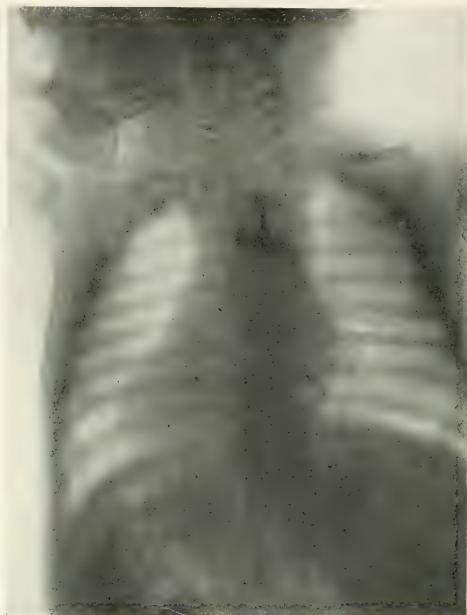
Radiograph of an infant of six months, showing a cuff-button which in three months ulcerated through from the esophagus into the trachea, causing almost fatal tracheal obstruction. Removed bloodlessly through the mouth by bronchoscopy without anesthesia.
